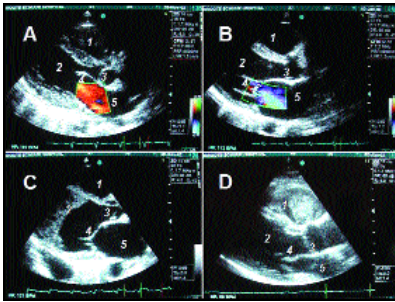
Echocardiography. These snapshots of videos demonstrate the detail visible with transthoracic echocardiography. A: normal diastolic flow as demonstrated with colour Doppler through the open mitral valve. The aortic valve is closed. B: mitral regurgitation demonstrated by Doppler. The mitral valve chordae are visible. The aortic valve is open. C: enormous thrombus filling 2/3 of LV in patient with cardiomyopathy. D: metastatic tumour noted in RV in patient who presented with haemoptysis. (1 = right ventricle (RV); 2 = left ventricle (LV); 3 = aortic valve; 4; mitral valve; 5 = left atrium.)
